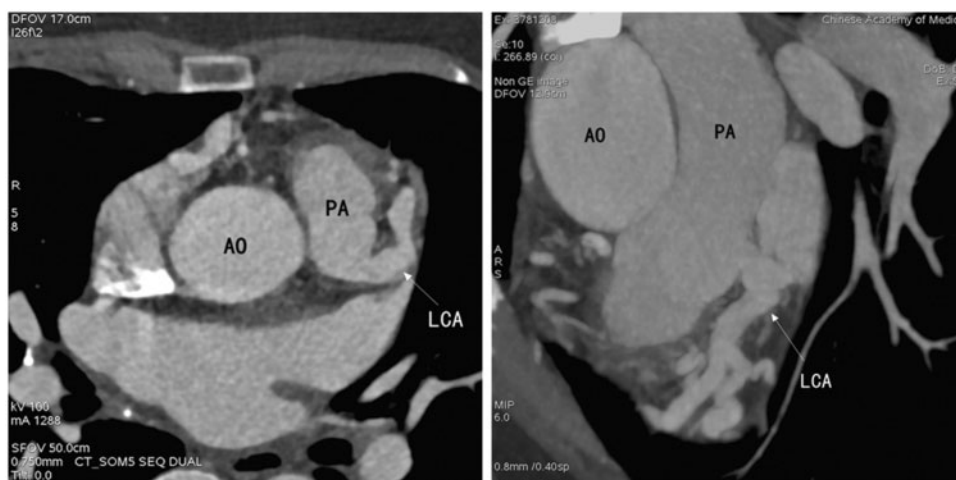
Before the Takeuchi repair, computed tomography angiography shows that the left coronary artery arises from the main pulmonary artery.
